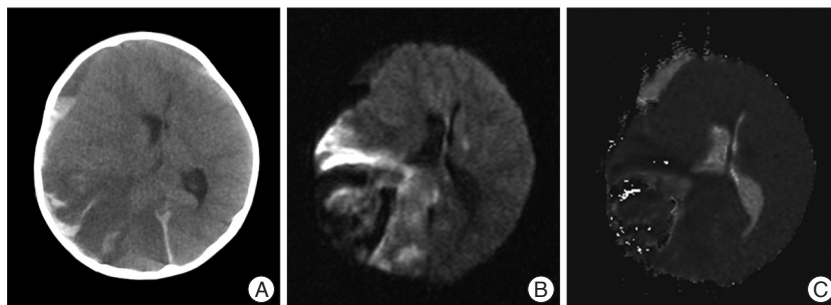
A : Non enhanced brain CT revealed an acute right-sided middle cerebral artery territory infarct with mass effect manifested as right lateral ventricular compression, attenuation of the basal cisterns and right convexity sulci effacement. Because of midline shift due to severe brain parenchymal swelling, posterior horn of lateral ventricle was not seen. And hemorrhagic transformation was also noted at same side area. B and C : DWI MRI scan of his brain revealed that lesion was appropriate for acute cerebral infarction with hemorrhagic transformation with significant mid-line shift. CT : computed tomography, DWI : diffusion weighted image, MRI : magnetic resonance imaging.
